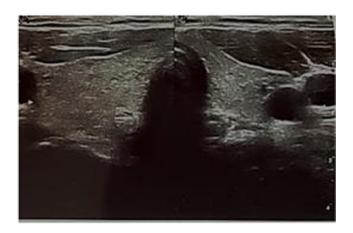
Ultrasound of the thyroid gland.
